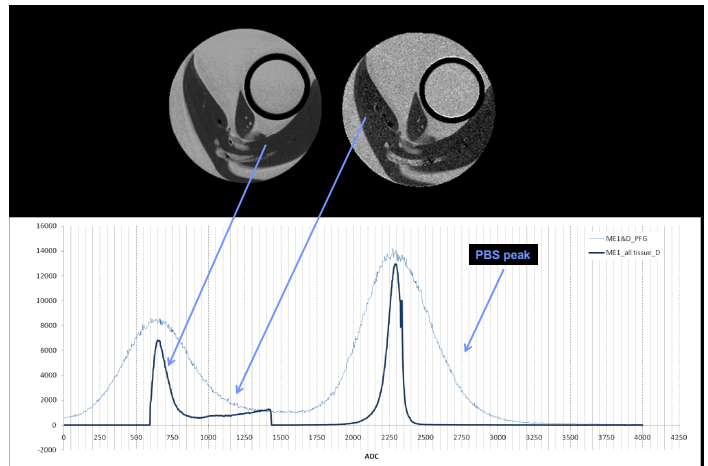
Comparison of ADC maps generated by CT-D (left) and PFG (right) techniques. Comparison of histograms shown below.
